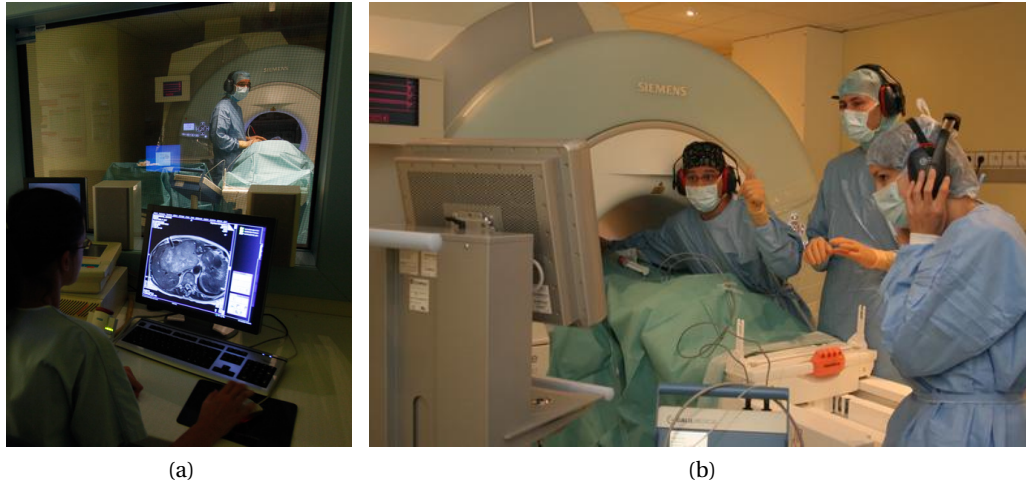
(a) Interventional MRI environment: physician inside the MRI room performing the intervention and technologist at the MRI console in the MRI control room. (b) Intervention in MRI with the physician lying inside the magnet to advance the needle based on the images displayed in real-time. The physician uses sign language for communication with the technologist in the MRI control room.
